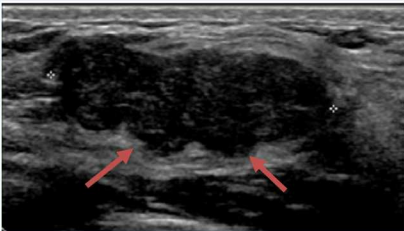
3.5 x 2.5 cm lobulated lesion on ultrasound with appearances in keeping with a FA or phylloides tumour. The lesion was previously biopsied and proven to be a FA however has now enlarged.
